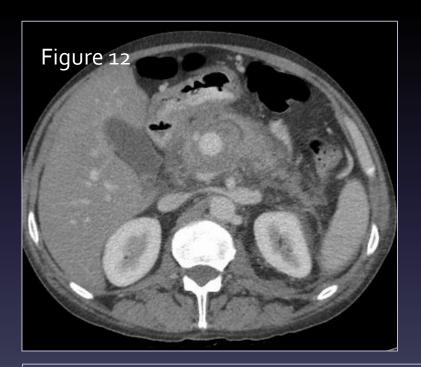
Axial post IV contrast CT post thrombin injection of the pancreatic head pseudoaneurysm demonstrating successful treatment of the pseudo-aneurysm. There is no residual vascular flow within the lesion (blue arrow). There are persistent features of acute pancreatitis – peri-pancreatic free fluid, inflammation and fat stranding.
